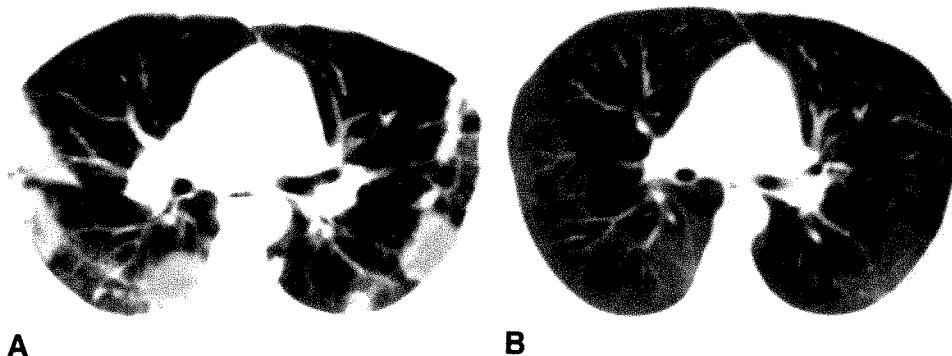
A, CT scan at level of bronchus intermedius shows peripheral air-space consolidation.
